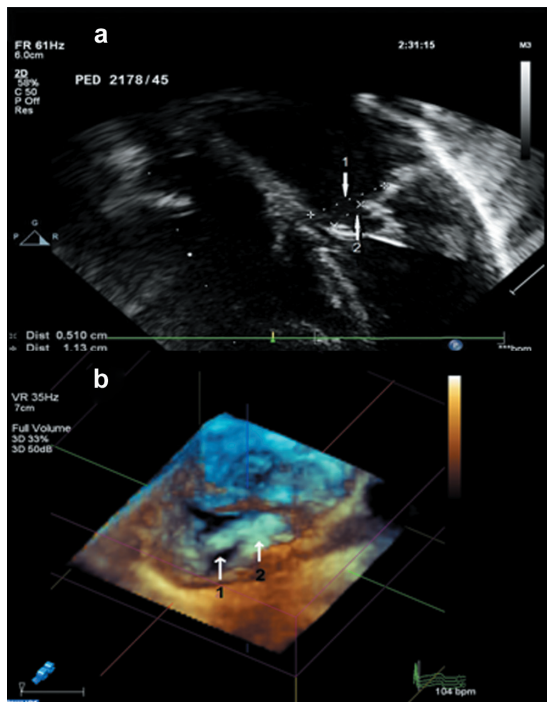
(a) Two-dimensional echocardiography showing an apical four-chamber view. Arrow one indicates the mitral valve (MV) annulus, and arrow two an abnormally bent posterior MV leaflet. (b) Real-time three-dimensional echocardiography image showing an en face view of the MV. Arrow one shows the MV orifice, and arrow two the intramitral ring.
